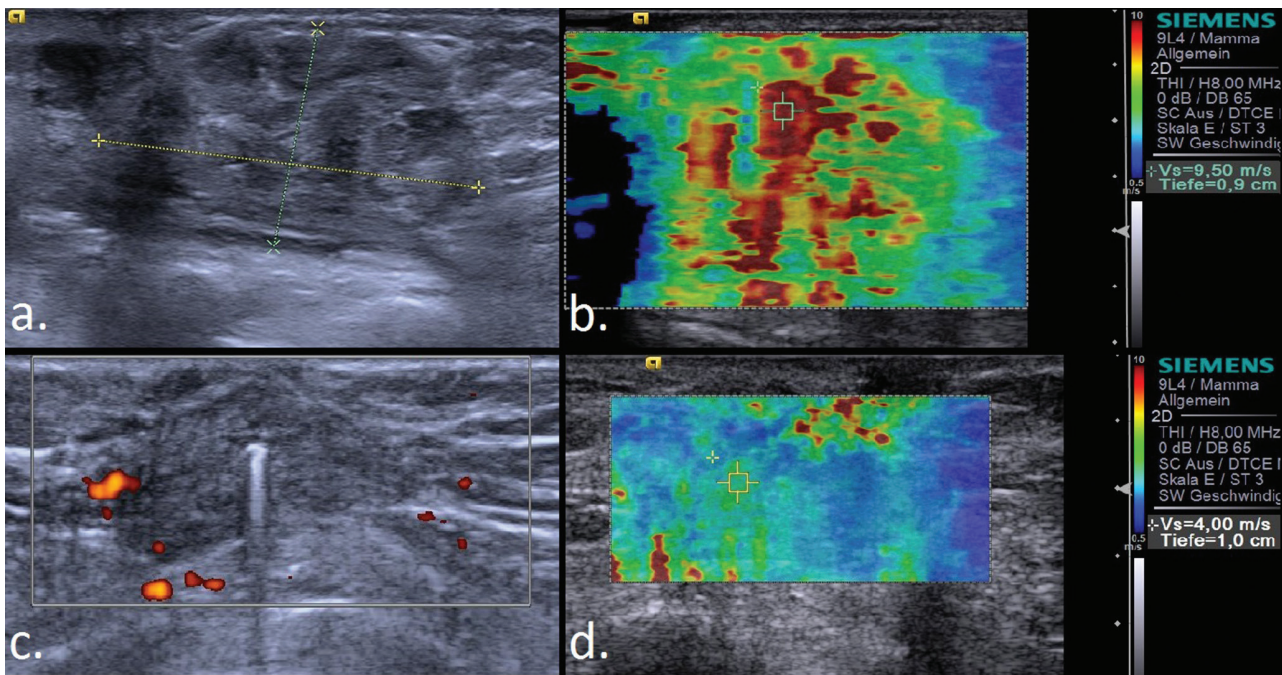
Sonography of a TN, G3 IDC at baseline (a. B-mode, b. ARFI elastography) and after 3 NAC cycles (c. B-mode, d. ARFI elastography). Comparison of B-mode images demonstrates a slight size decrease (<30%), formally classified as stable disease. ARFI elastography however, shows a significant softening of the tumor, as a sign of response to treatment. ARFI: acoustic radiation force impulse
